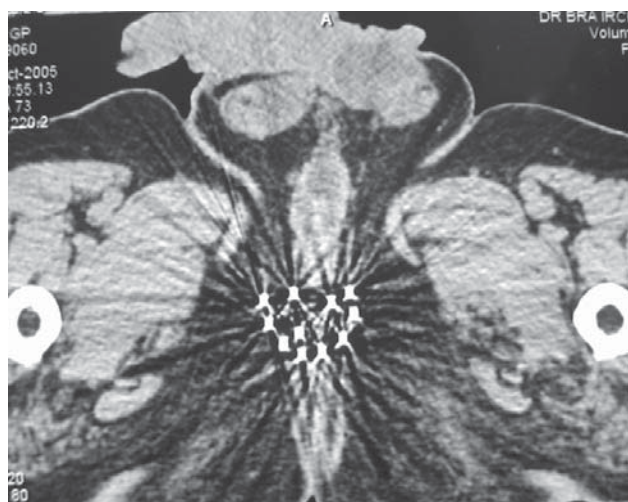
Axial CT image at the level of prostate showing the final placement of the needles for interstitial brachytherapy. Each needles were individually guided using TRUS.
